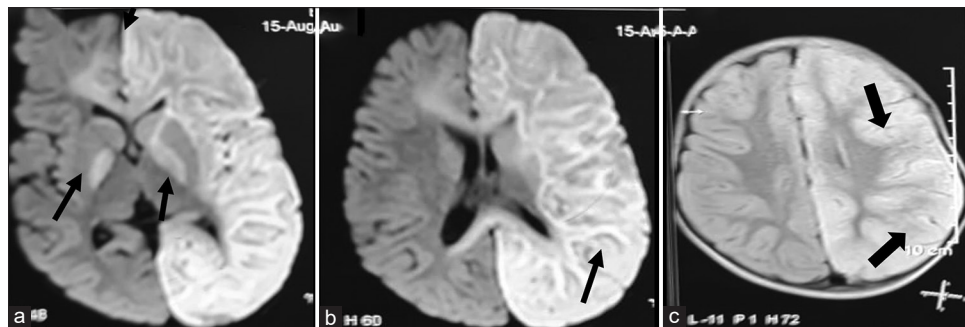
(a and b) Magnetic resonance imaging brain shows diffuse oedema of the left hemisphere, corpus callosum, left internal capsule and bilateral globus pallidus regions appearing hyperintense (black arrows) on axial diffusion-weighted imaging and hyperintense (black arrows) on fluid-attenuated inversion recovery (c) sequences on 7th day at 13 months of age when admitted to the hospital (black arrows).
